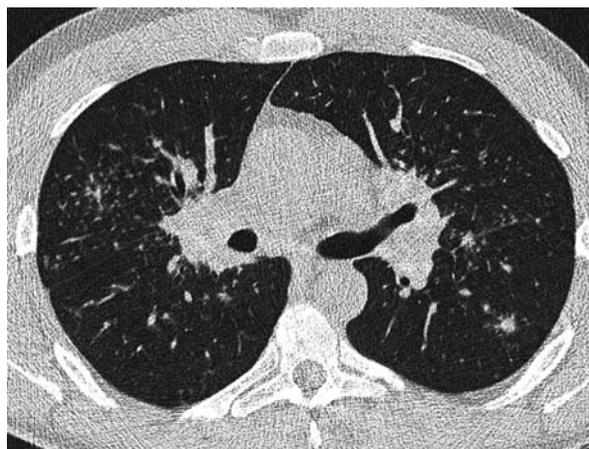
Imaging results of a 36-year-old man with WTC-related sarcoidosis. Axial HRCT image showing typical bilateral perilymphatic nodules in the perihilar regions. PFTs were normal.
